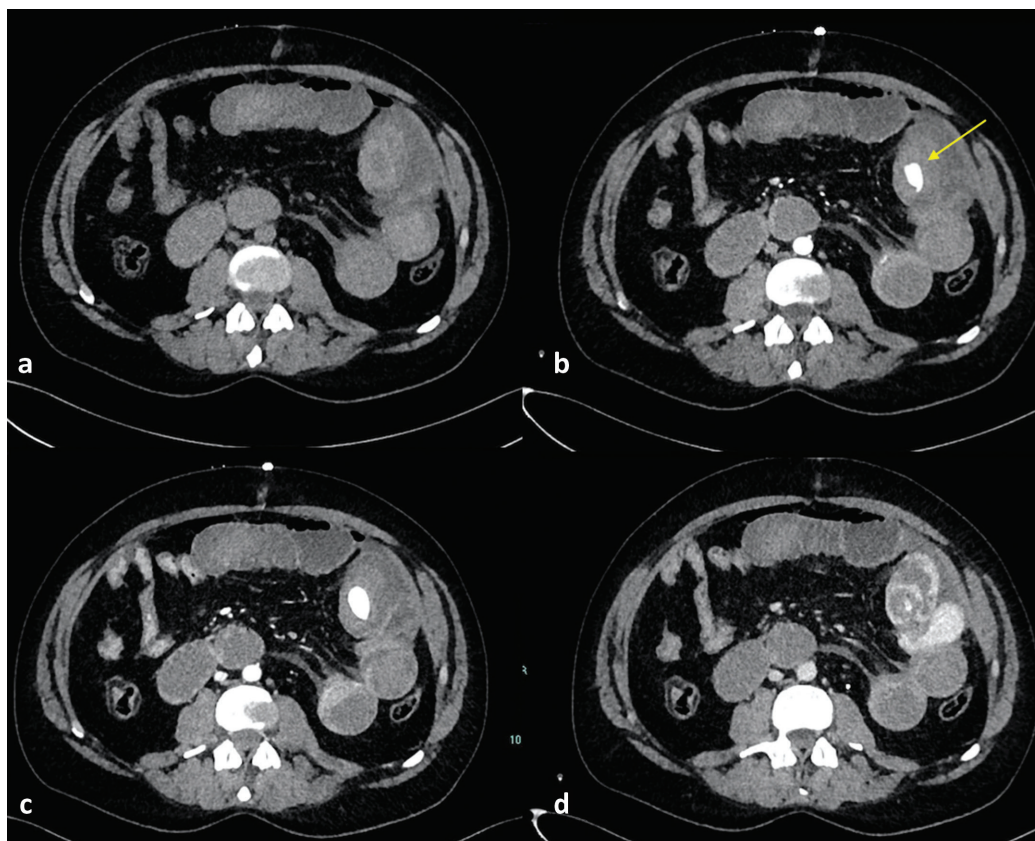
Contrast-enhanced abdominal CT scan, in the axial planes, with non-contrast (a), arterial (b), venous (c), and delayed (d) phases. The CT scans showed a large blush of contrast agent in the arterial phase (b, arrow) increasing in the later phases (c,d) in the lumen of a jejunal loop in the left lumbar region, indicative of severe active bleeding and associated with profuse blood in the lumen of multiple jejunal loops downstream (d). The CT scan also showed hemoperitoneum adjacent the jejunal loops in the left lumbar region.
